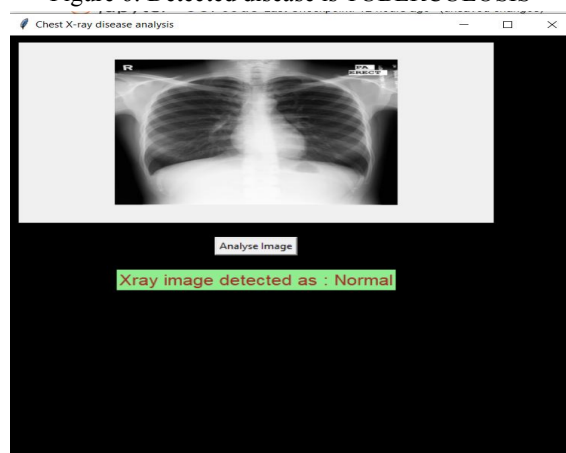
The detected x-ray is NORMAL
